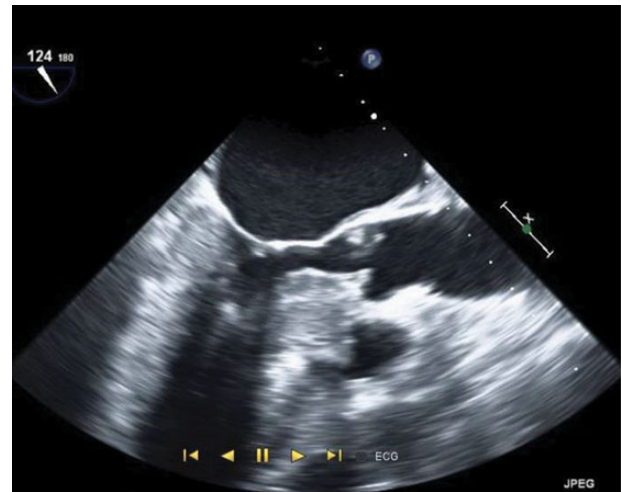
Severe asymmetric hypertrophy of subannular muscular left ventricular outflow tract (as identified echocardiographically in the parasternal long-axis view).
